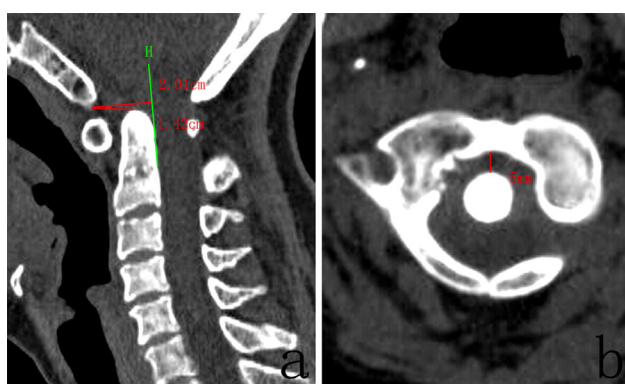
Sagittal CT reconstruction a demonstrating exceeding of Harris Rule of Twelve (the basion-dens interval = 14 mm, basion-axial interval = 20 mm). Axial CT reconstruction b demonstrating dislocation of atlantoaxial (AAI = 5 mm)
